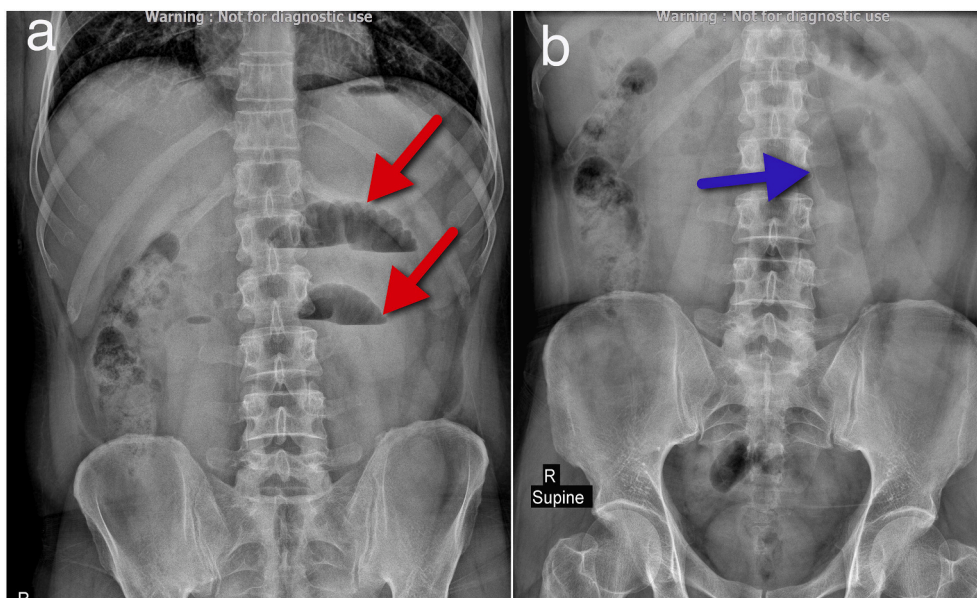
Plain abdominal radiographs. a) multiple air-fluid levels is shown (red arrows) in upright x-ray. b) small bowel loop with a “stack of coins” sign is indicated (blue arrow). (For interpretation of the references to color in this figure legend, the reader is referred to the web version of this article.)
